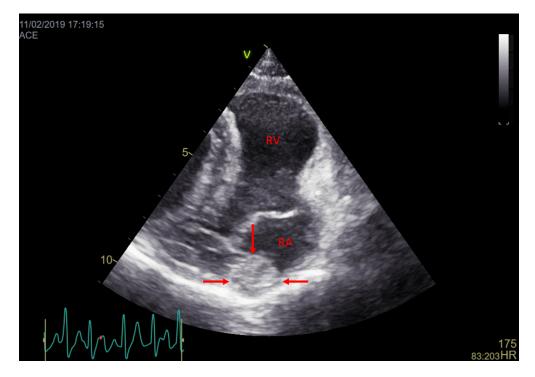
Echocardiographic images of the right atrial mass (arrows) from a non-standard left apical 4 chamber view optimized for the right heart (moved cranially with the left heart on the left of the image). The mass is showed here in the dorsal aspect of the right atrium.
